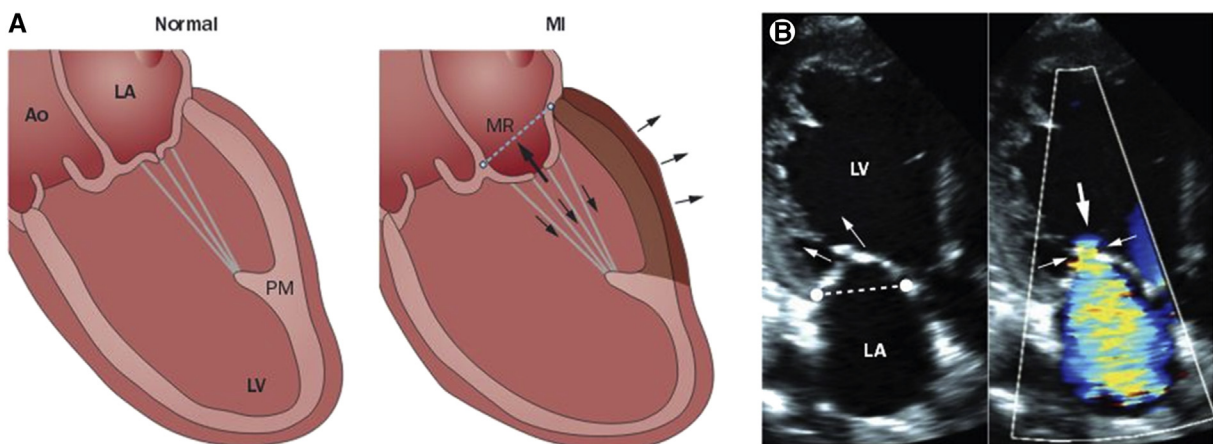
Mechanism of ischemic mitral regurgitation. A, Mechanism of ischemic mitral regurgitation caused by increased mitral leaflet tethering owing to left ventricular remodeling after myocardial infarction (*shaded wall*) with outward bulging (*arrows on the outer surface of the heart*). Leaflet closure is restricted by increased tethering forces on the leaflets exerted via the chordae (*arrows within the heart, exceeding normal on the left*). B, Echocardiogram from a patient with inferior wall infarction and tethered mitral leaflets (*arrows in left panel*) with characteristic anterior leaflet bend and concavity toward the left atrium (*LA*) indicating chordal tethering, mitral regurgitation (*MR*) orifice (*small arrows in right panel*), and MR flow (*large arrow in right panel*). Ao, Aorta; LV, left ventricle; PM, papillary muscle; MI, myocardial infarction. Reprinted by permission from Macmillan Publishers Ltd: *Nature Reviews Cardiology*,² copyright 2015.
